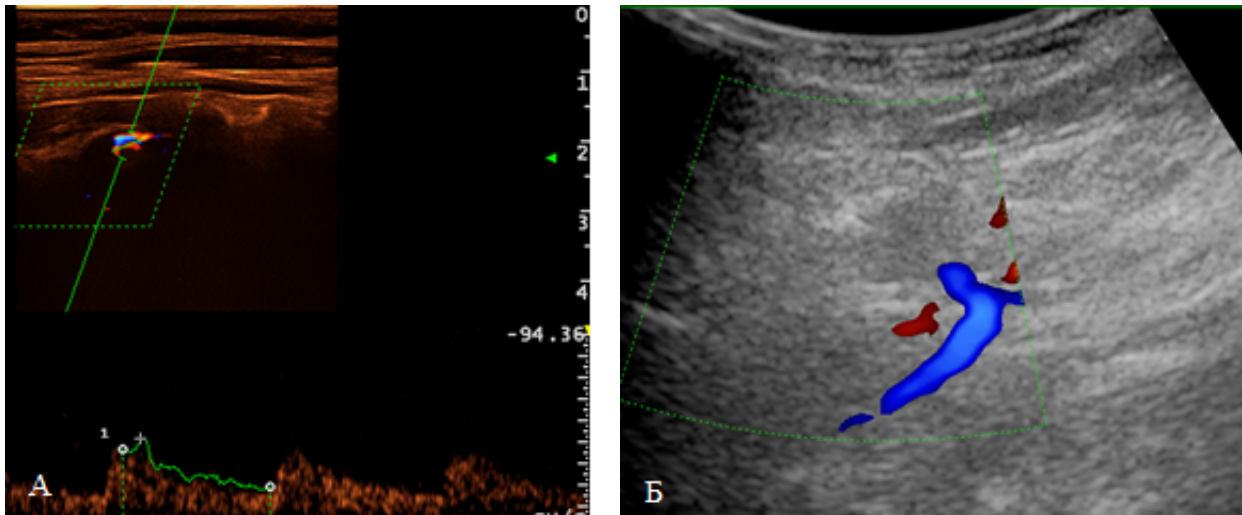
Dopplerography of the vertebral arteries. Craniovertebral department. A – visualization using a linear sensor, B – visualization using a cavity sensor.
